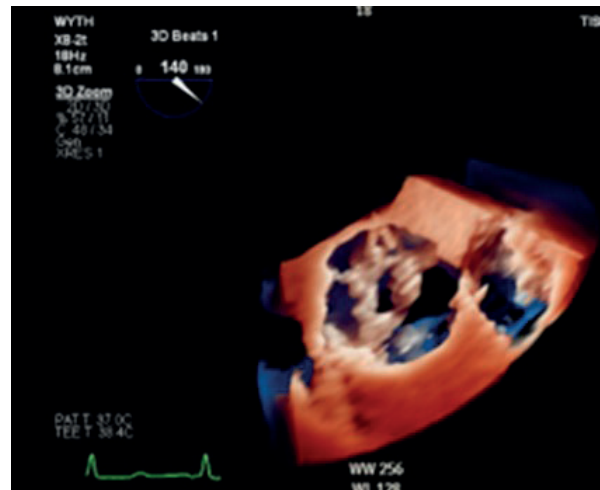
Transoesophageal images showing bicuspid aortic valve with reduced leaflet excursion. Right, 3D image of the AV
